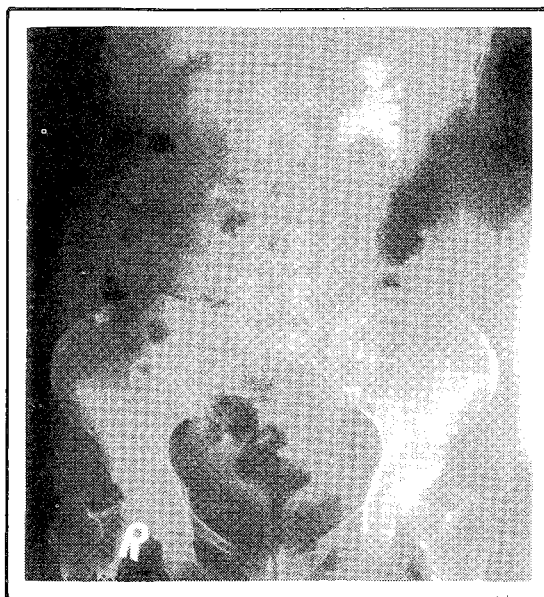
Immediate retrograde pyelogram studies after ultrasonic lithotripsy of an upper ureteric stone: Note extravasation.
